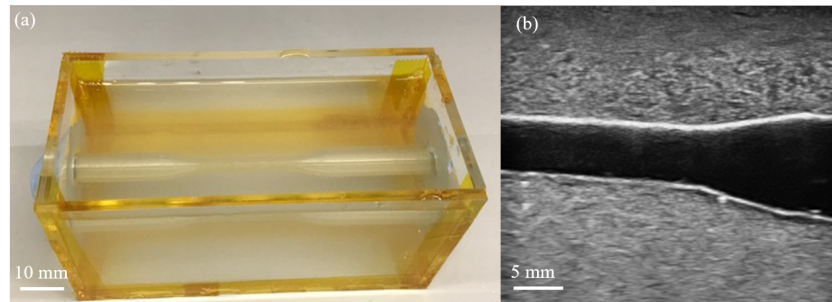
(a) Photo of stenosed vessel structure submerged in PVA-c, before one freeze-thaw cycle (b) longitudinal ultrasound image of the vessel
